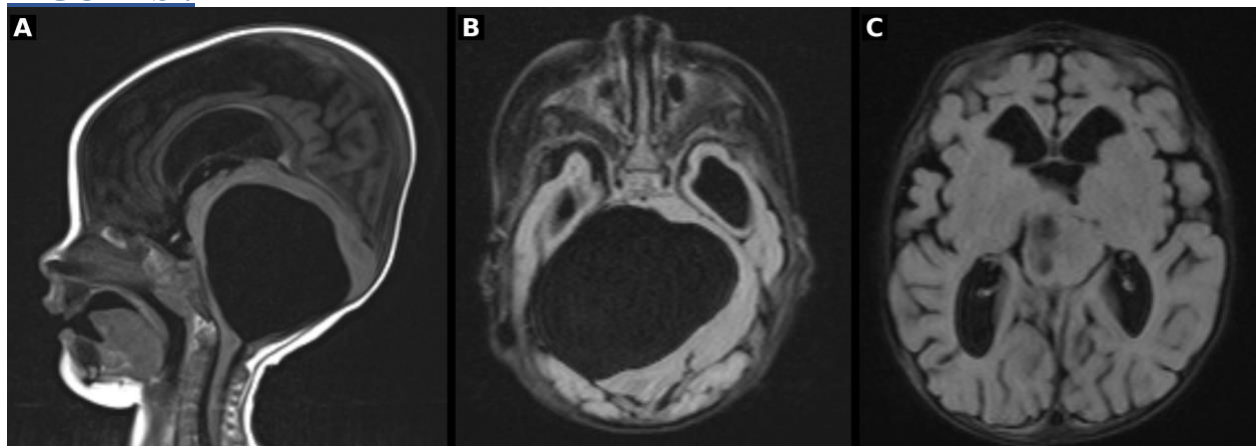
Brain MRI (T1-weighted sequences) of the 5-month-old infant showing a large, well-defined, thin-walled cystic formation of the fourth ventricle. (A) Midsagittal T1-weighted image demonstrating the hypointense cystic lesion occupying the posterior fossa, with mass effect on the cerebellum and brainstem and upstream dilatation of the third ventricle. (B) Axial T1-weighted image at the level of the posterior fossa showing the cystic formation with regular margins, exerting mass effect on the adjacent cerebellar and pontocerebellar structures. (C) Axial T1-weighted image at the level of the lateral ventricles showing triventricular dilatation, consistent with obstructive hydrocephalus secondary to fourth ventricular outlet obstruction.
